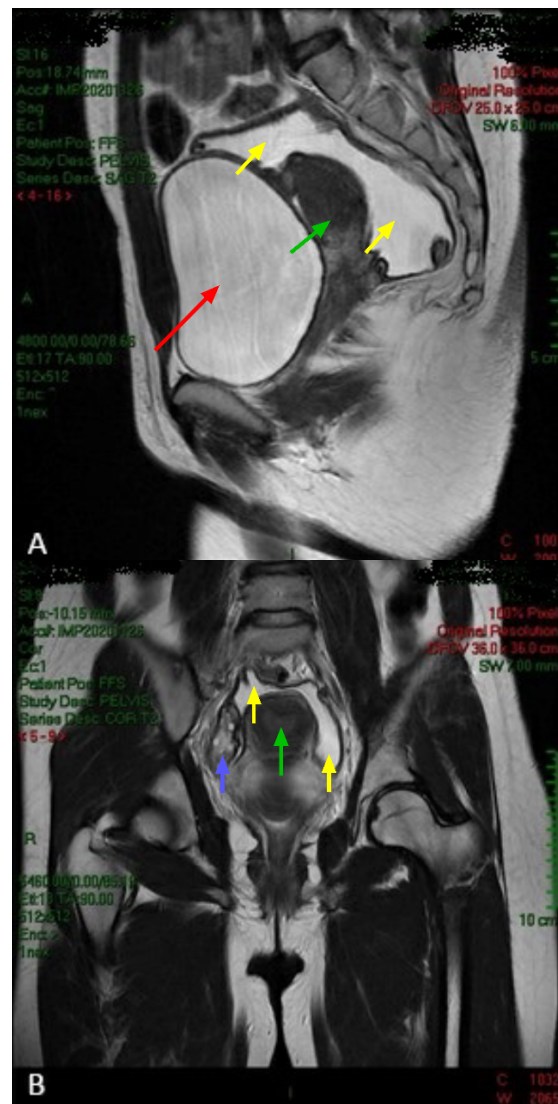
(A-B) MRI of the pelvis showing the fluid-filled cyst in the Douglas space, extending to the parauterine space on T2-weighted images in the sagittal cut (A) and coronal cut (B). The yellow, green, red and blue arrows indicate the pelvic cyst, the body of the uterus, the urinary bladder, and the right ovary, respectively.
